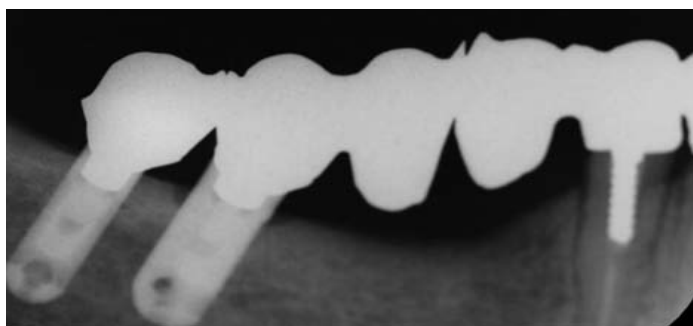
Radiograph in 1998. A TISP was created with two pontics because the implants used as terminal abutments were placed too posteriorly.
